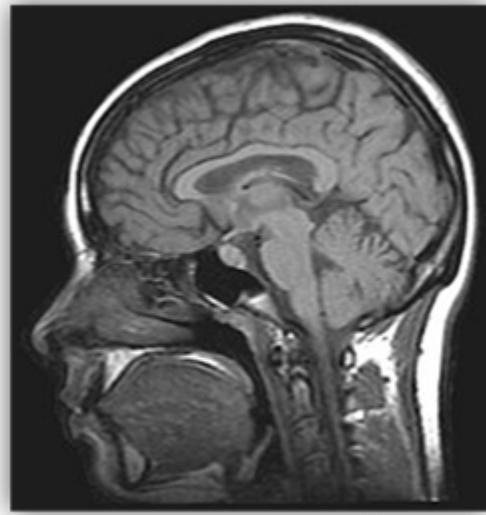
MRI brain image [6]
